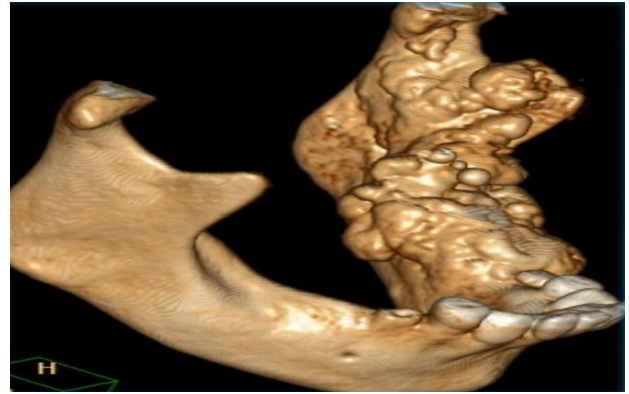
Perforation of the lingual cortex as depicted by 3D-CT.
